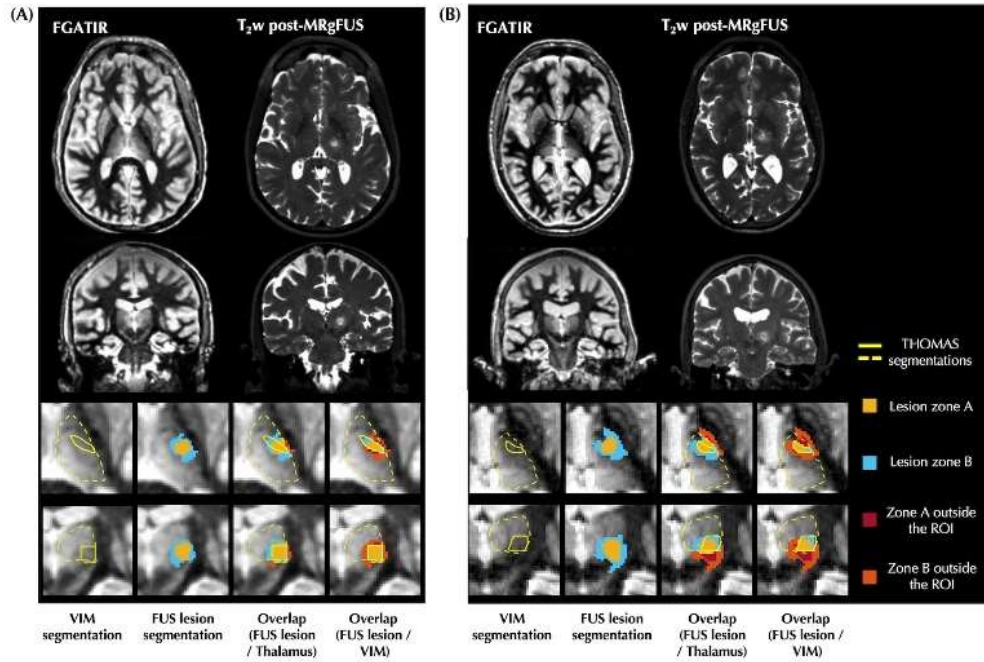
Example THOMAS segmentations (yellow line: thalamus; white line: VIM nucleus) and MRgFUS treated lesions (magenta: Zone A; cyan: Zone B) are shown in axial and coronal views. In the patient with side effects (A), lesions extend farther out of the thalamus and segmented VIM, compared to the patient without side effects (B). FGATIR, Fast Gray Matter Acquisition T1 Inversion Recovery; MRgFUS, MR-guided focused ultrasound; THOMAS, Thalamus Optimized Multi Atlas Segmentation; VIM, ventral intermediate nucleus; ROI, region of interest.
